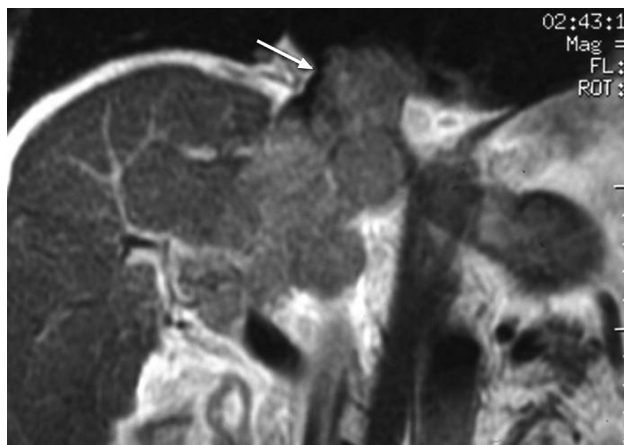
On T2-weighted coronal MR image of a 58-year-old male with diffuse HCC, the extension of the left hepatic vein thrombus into the right atrium is demonstrated (arrow).
